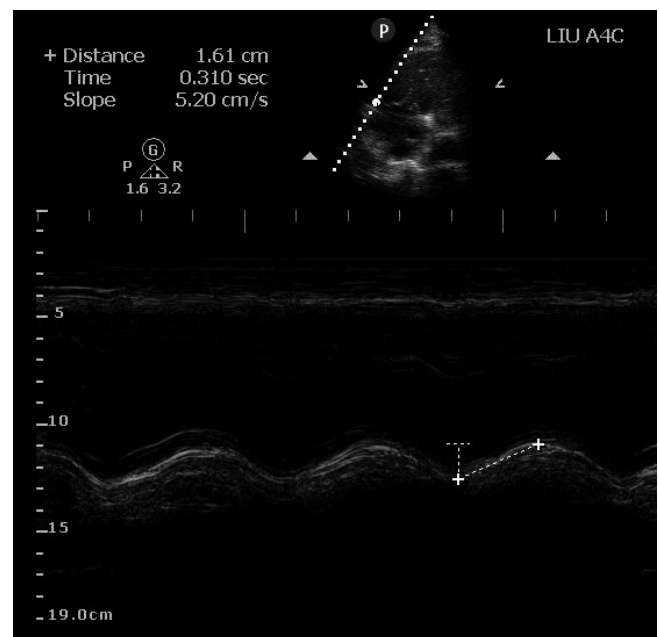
Measuring TAPSE. TAPSE is measured in the apical four-chamber view with the M-mode cursor placed over the lateral tricuspid valve annulus. This creates a wave form, which can then be measured from trough to peak. TAPSE = tricuspid annular plane systolic excursion.
